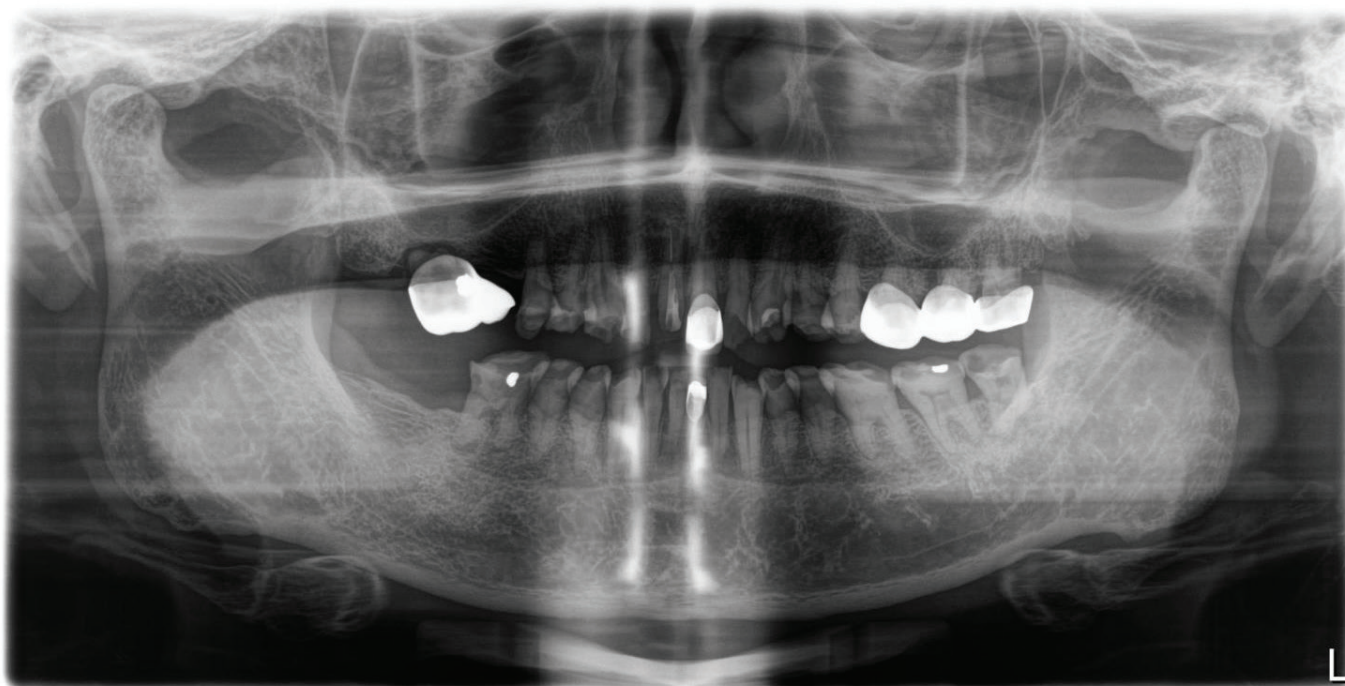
Panoramic film shows 17 severe bony destruction with ill-fitting prosthesis, 11 prior root canal treatment with crown dislodged, ill-fitting crown on 21, 26, 27 and 28, periapical lesion on 46 distal root.
